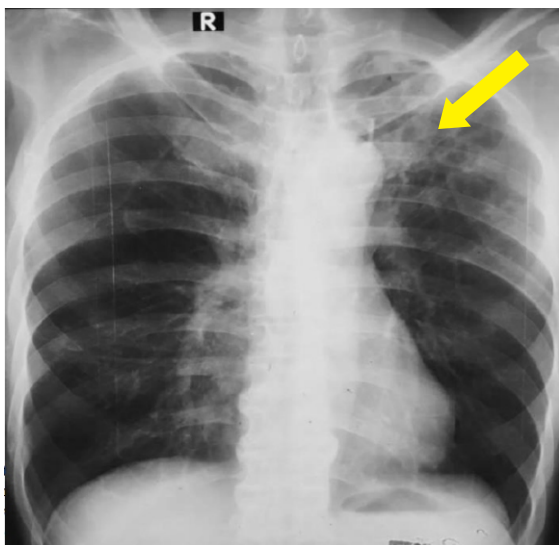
Left apical cavitation demonstrated on Chest X-ray (arrow)
